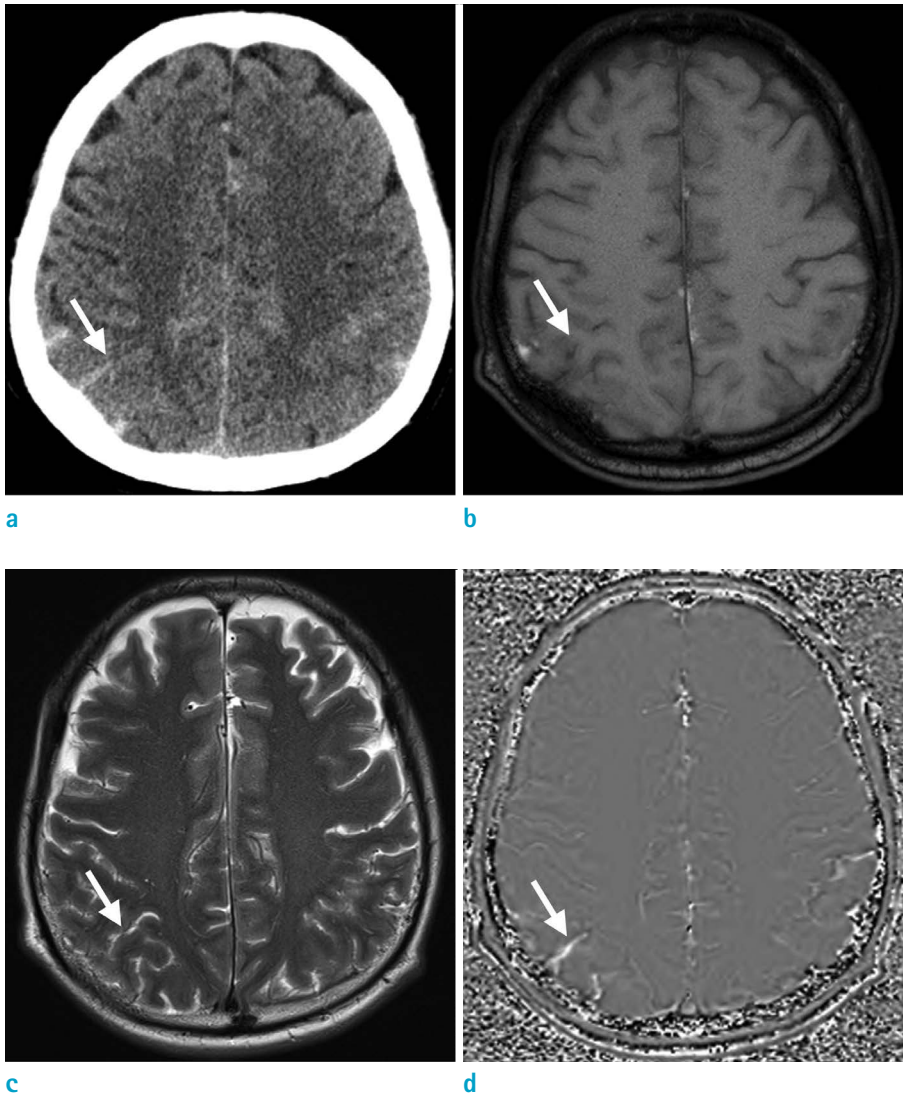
A case of acute subarachnoid hemorrhage (arrows). High density in the right parietal sulci on the pre-contrast CT (a), not definitely delineated on T1- and T2-weighted images (b, c), and homogeneous hyper-signal intensity on phase image (d).
